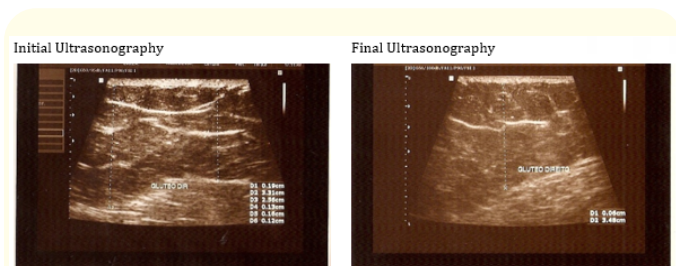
Evaluation by ultrasonography of the fat thickness and fibrous septa before and after the treatment with ultracavitation.
